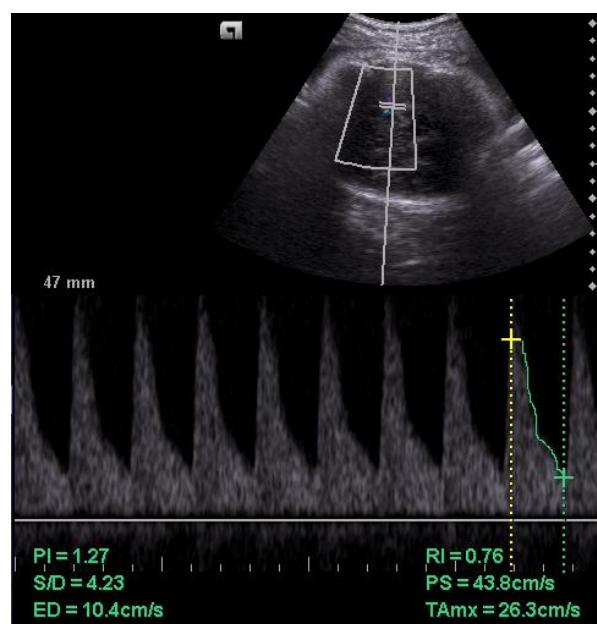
Normal Middle Cerebral Artery Doppler
